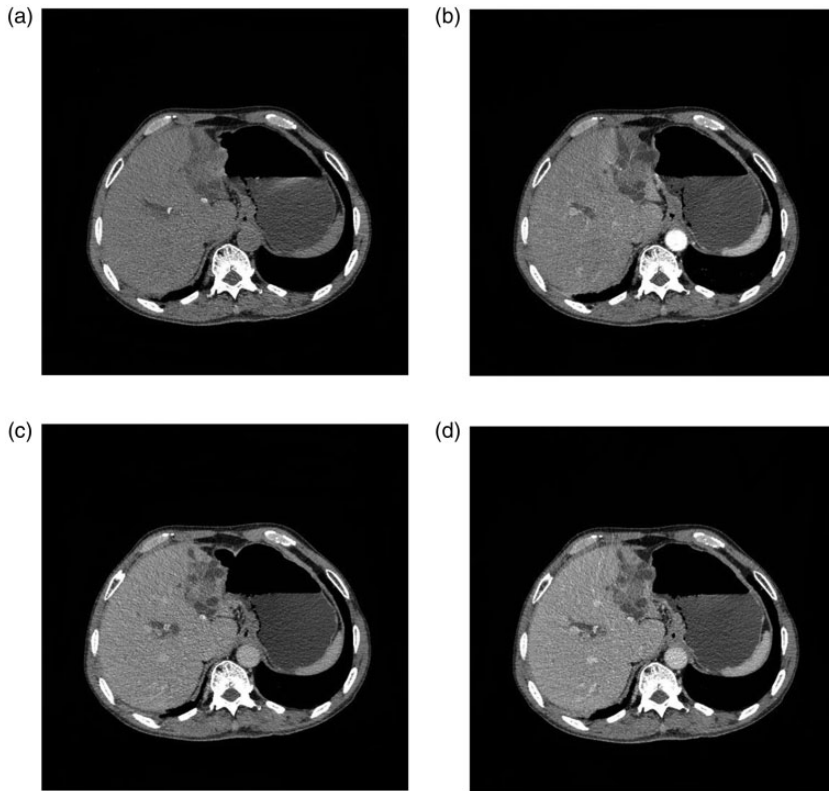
Axial computed tomography findings in the described patient with sarcomatoid intrahepatic cholangiocarcinoma. (a) and (b) Arterial phase reveals part of the left outer lobe of the liver that has expanded to the thickness of the bile ducts, and strengthening is obvious. (c) and (d) The lesion shows no contrast enhancement in venous or late phase reveals.
